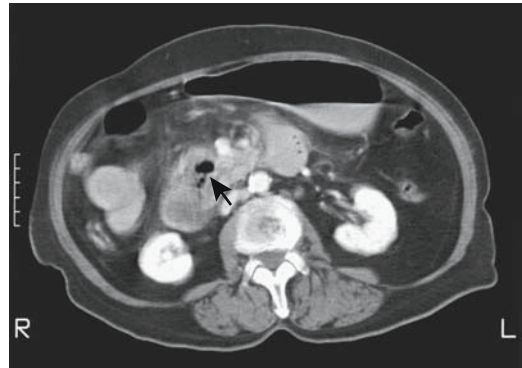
Duodenal diverticulum. CT identifies gas in the pancreatic head (arrow). Initially this gas was believed to be in an abscess in this patient with pancreatitis. (Courtesy of Patrick Fultz, M.D., University of Rochester.)
